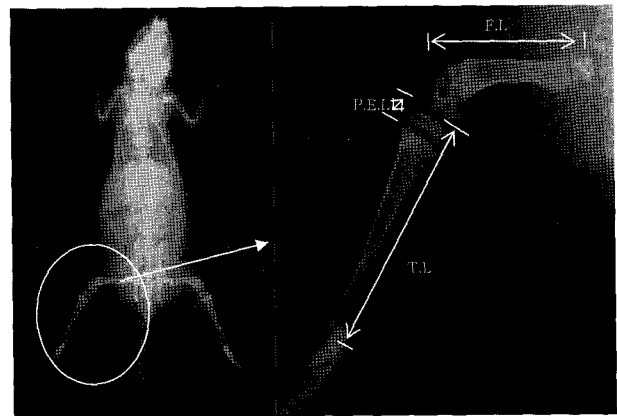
Radiograph of a longitudinal bone showing femur and tibial morphometric parameters. TL, total tibial length; PEL, proximal epiphysis length; FL, femur length.
